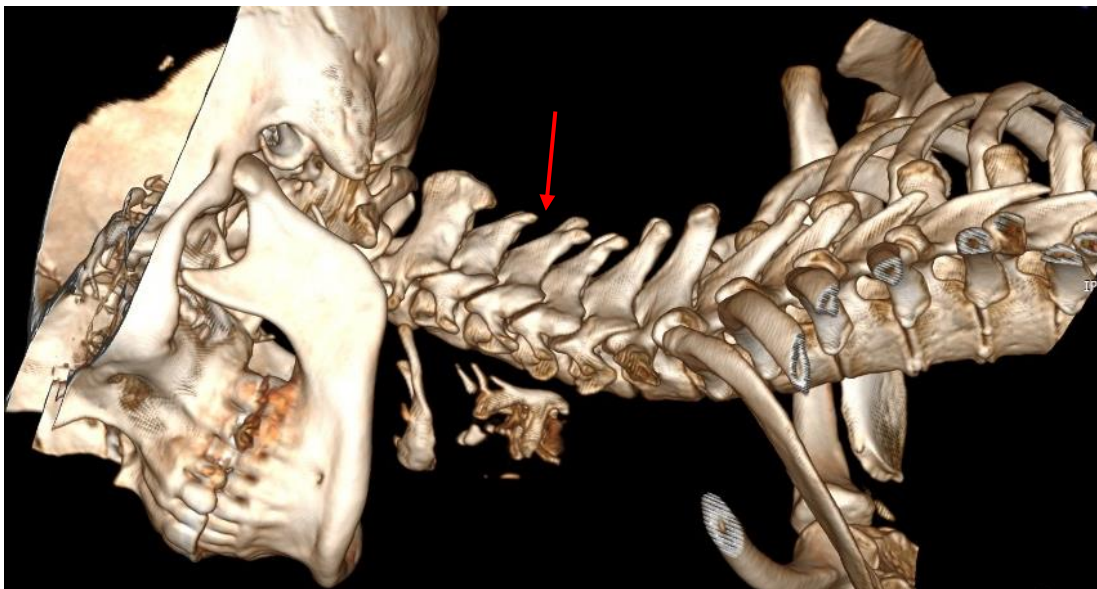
This is NN's cervical spine in neutral prone position (CT). The red arrow indicates the downward thrust.
